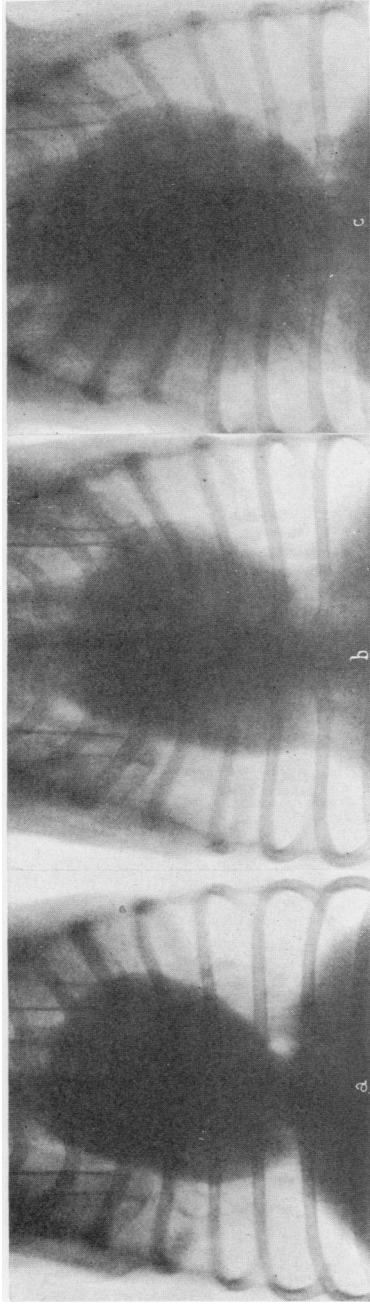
ROENTGENOGRAMS OF EXPERIMENT 12
